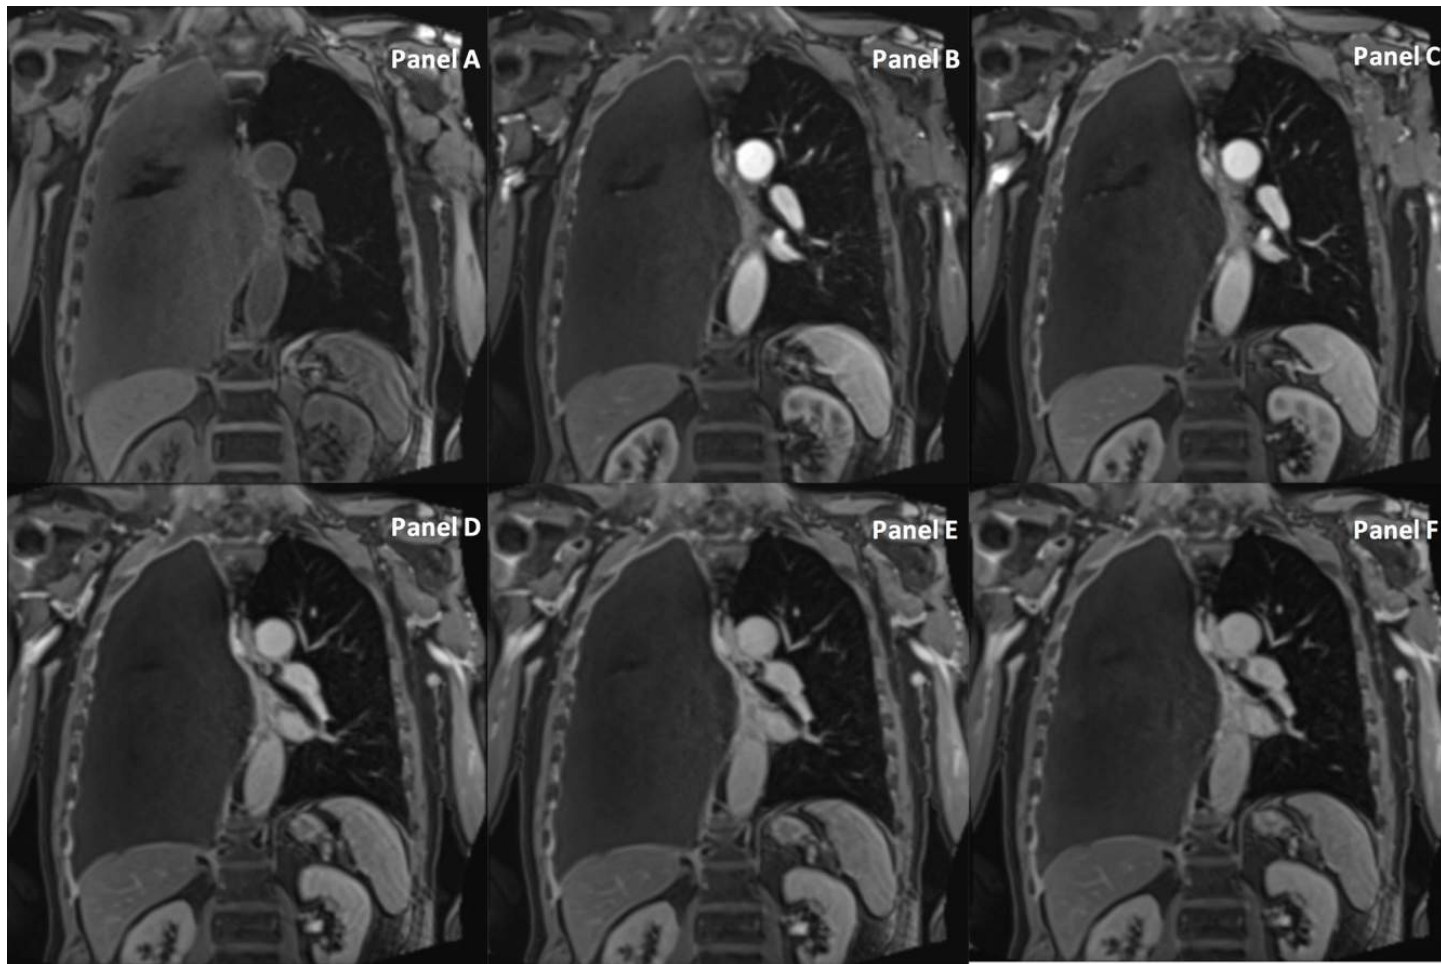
Isotropically-acquired, contrast-enhanced MR images acquired over time pre-contrast (Panel A) and 40 seconds (Panel B), 80 seconds (Panel C), 4.5 minutes (Panel D), 9 minutes (Panel E) and 13.5 minutes (Panel F) post-administration of intravenous Gadobutrol
